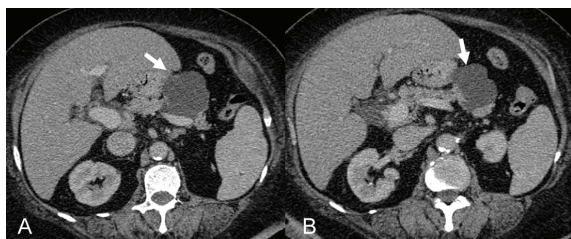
A 76 year-old female with chronic dyspepsia. Axial post contrast CT (A, B) scan revealed multi-locular macrocystic lesion with no mural nodule at body of pancreas (arrow). She had been distal pancreatectomy with splenectomy and pathology showed mucinous cystic neoplasm
